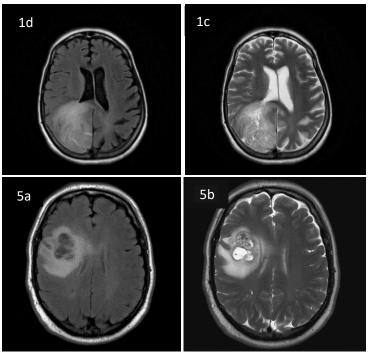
1d: axial T2 FLAIR; 1c: T2 WI. 5: Glioblastoma NOS, 55year-old, male. Presentation: headaches. 5a: axial T2 FLAIR; 5b: T2 WI. Adapted from: 1: case of Dr Mohammad A. ElBeialy, Radiopaedia.org, rID: 23473 and 5: Case of A.Prof Frank Gaillard, Radiopaedia.org, rID: 5322
